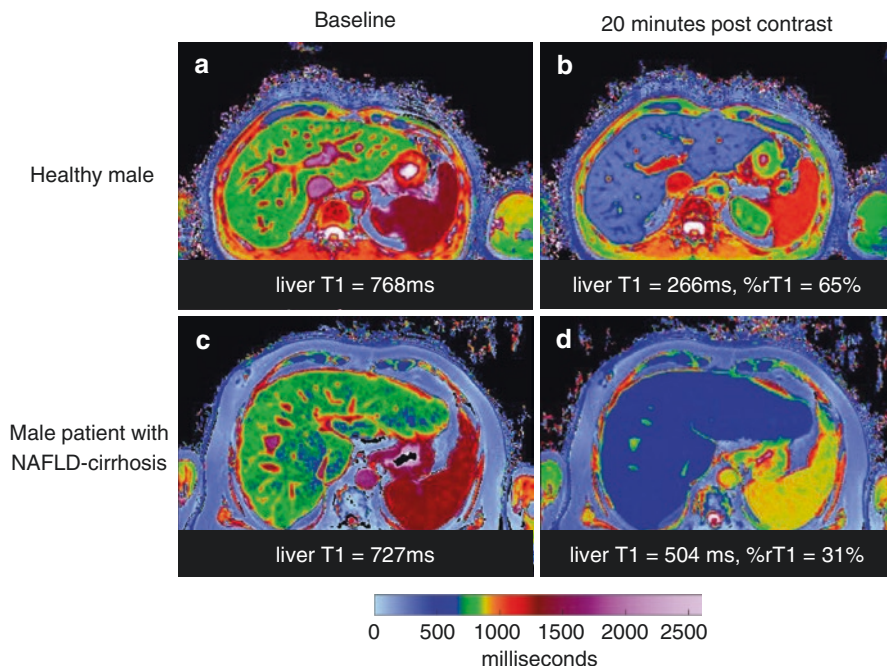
Gadoteric acid enhanced MRI. The relative reduction in T1 20 min after gadoteric acid injection in a healthy male and patient with cirrhosis from non-alcoholic fatty liver disease (NAFLD). In the healthy male, T1 decreases from (a) baseline of 768 ms to a (b) post contrast T1 of 266 ms, a relative reduction (percentagerT1) of 65%, while in the case of the patient, the T1 decreases from (c) a baseline of 727 ms to a (d) post contrast T1 of 504 ms, a relative reduction of 31%
